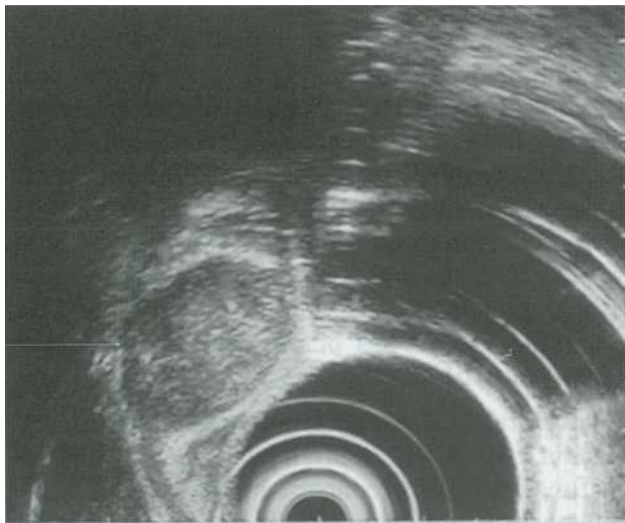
Endoscopic ultrasonographic feature of a gastrointestinal stromal tumor localized at the stomach. Arrow shows a mass arising from muscularis propria
